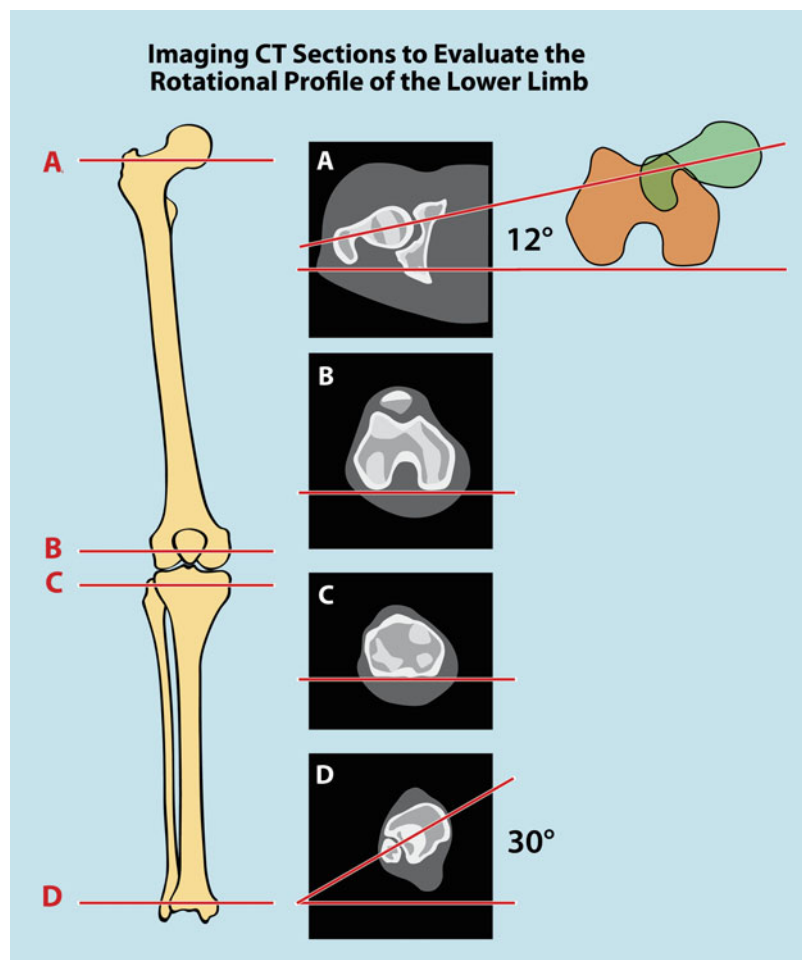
CT scan measurement of rotational profile, using transverse cuts through. (a) Proximal femur (femoral anteversion) – normal 12°. (b) Distal femur (femoral condyle alignment). (c) Proximal tibia. (d) Distal tibia
